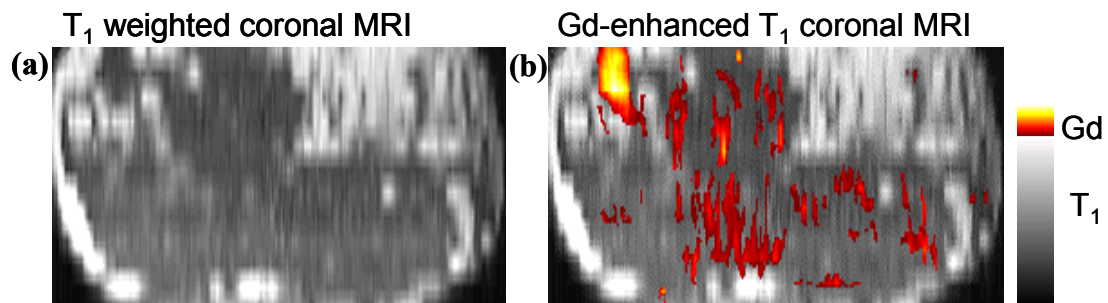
An MRI anatomical coronal slice (a) and the same coronal slice with superimposed enhancement due to Gd administration.
